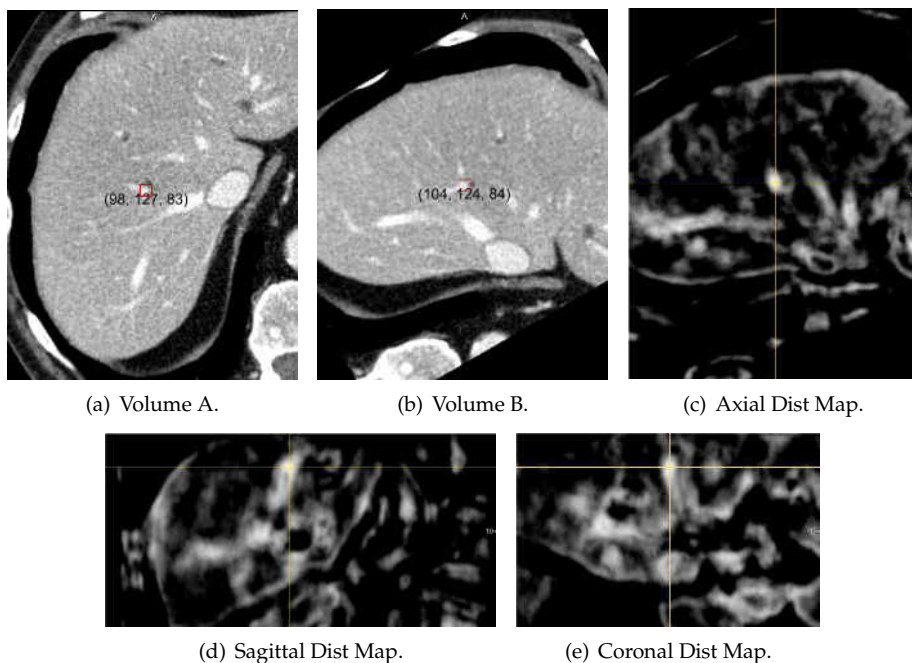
Liver CTA volume: A landmark location is selected in Volume A. The same landmark location is then searched in the Volume B; a) Volume A, b) Volume B: Obtained by rotating Volume A on axis $(0, 0, 1)$ by $\frac{\pi}{3}$ radians, c) The axial Chi-square distance map, d) The sagittal Chi-square distance map and e) The coronal Chi-square distance map. Parameters - Sampling Radius $R = 5$; Descriptor Radius $K = 5$; Sample points $P_1 = 42$.
